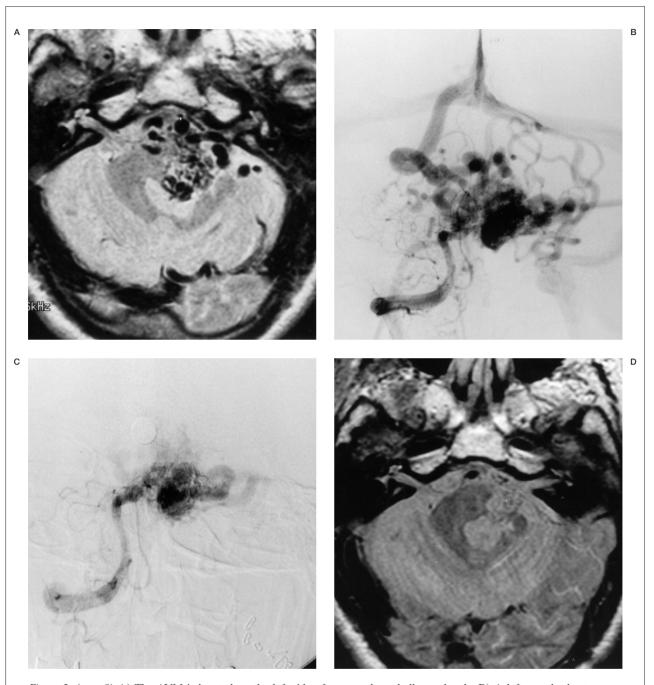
(case 9) A) The AVM is located on the left side of pons and cerebellar peduncle. B) A left vertebral artery angiogram showing the AVM mainly fed by branches from left anterior inferior cerebellar artery (AICA) C) Left vertebral angiogram after three repeated embolizations for AICA division using liquid coils (10 type, straight 2 cm x 27) D) MRI at 20 months after radiosurgery, showing disappearance of the AVM.
